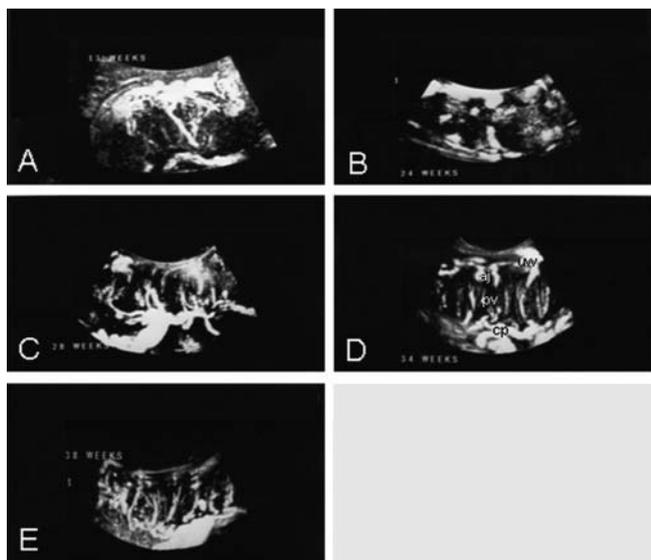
Power Doppler ultrasonographic images from different placentae of 13, 24, 28, 34 and 38 weeks of gestation. Blood flow within the uterine wall (uw) is always on top of the images with inflow via arterial jets (aj) in the intervillous space. The flow of maternal blood within the intervillous space is depicted by grey shading. Flow within the placental villi (pv) can be seen best in 28 to 38 weeks. Flow within the chorionic plate (cp) is always on the bottom of the images; sometimes also the flow within the umbilical cord (uc) is visible.
